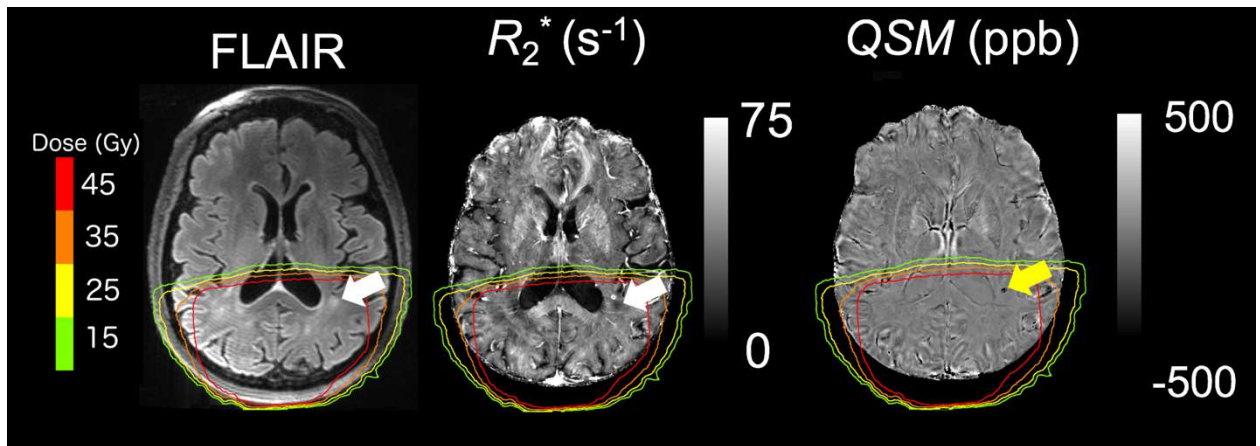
Patient 3 showing periventricular lesions that appear to be venocentric as indicated by the white arrow on FLAIR (hyperintense) and R_2^* (hypointense). Adjoining to the lesion, a microbleed is evident on R_2^* , which is indicated by a yellow arrow on QSM
